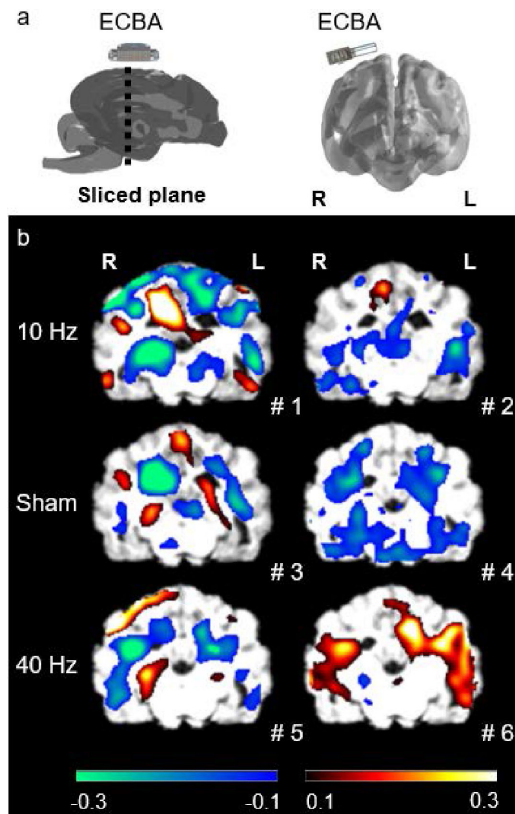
(a) Position of implanted ECBA in brain at sagittal and coronal views, (b) PET-CT scan of all subjects (#1 to #6) where ECBA was located in coronal plane in (a).
